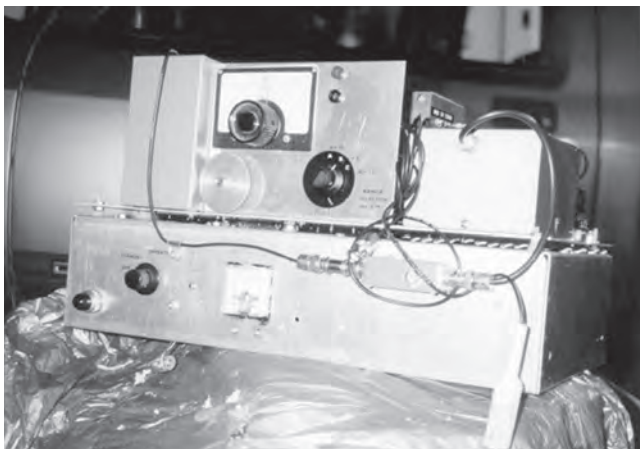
Donald Baker, a member of Rushmer's team, introduced a pulsed-Doppler system in 1966.
